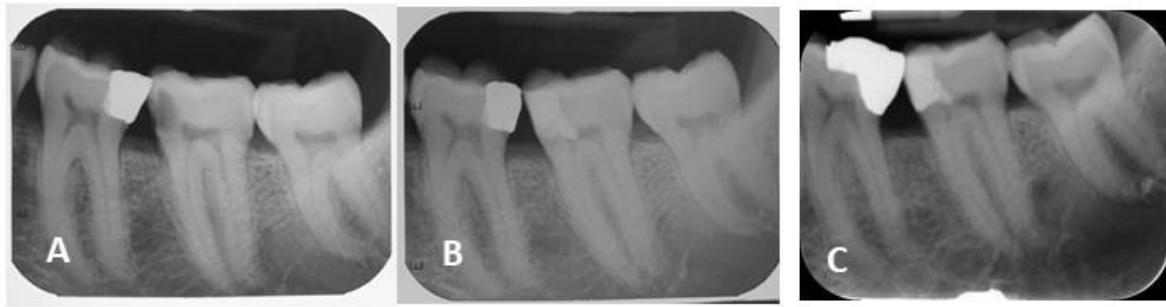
Radiographs of 48-year old male patient with signs and symptoms clinically suggestive of irreversible pulpitis and normal periapex in tooth 37 A: Preoperative radiograph, B: Immediate postoperative radiograph after partial pulpotomy using ProRoot MTA, C:5-year recall showing normal periapex.
